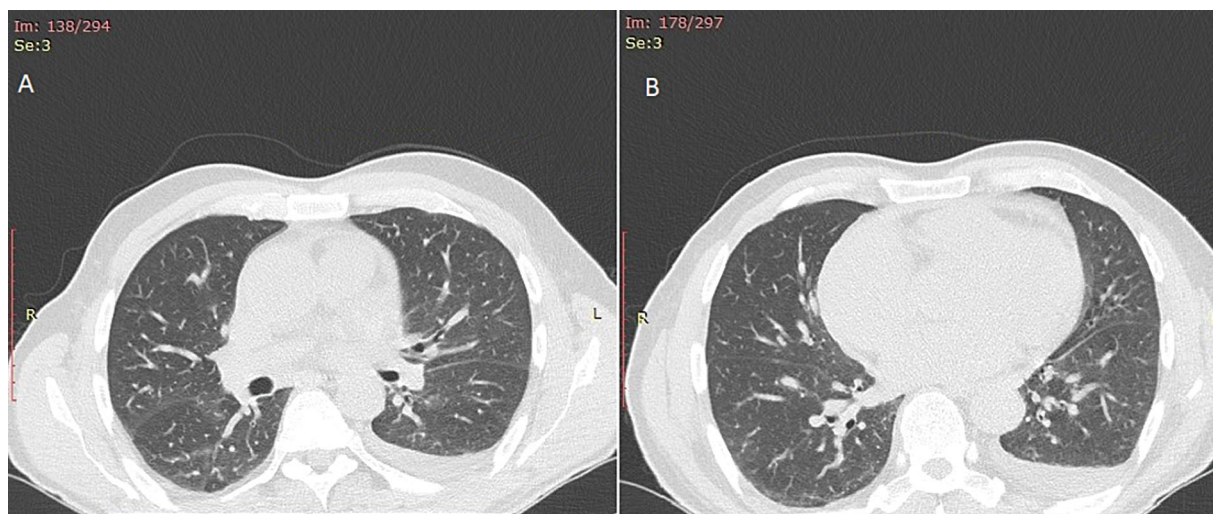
Computed tomography of the chest: A. Trace amount of fluid in the pericardium (apex area) and small areas of densities in the left lung, in the dorsal parts, and the vicinity of the fluid; B. A small amount of fluid in the left pleura
